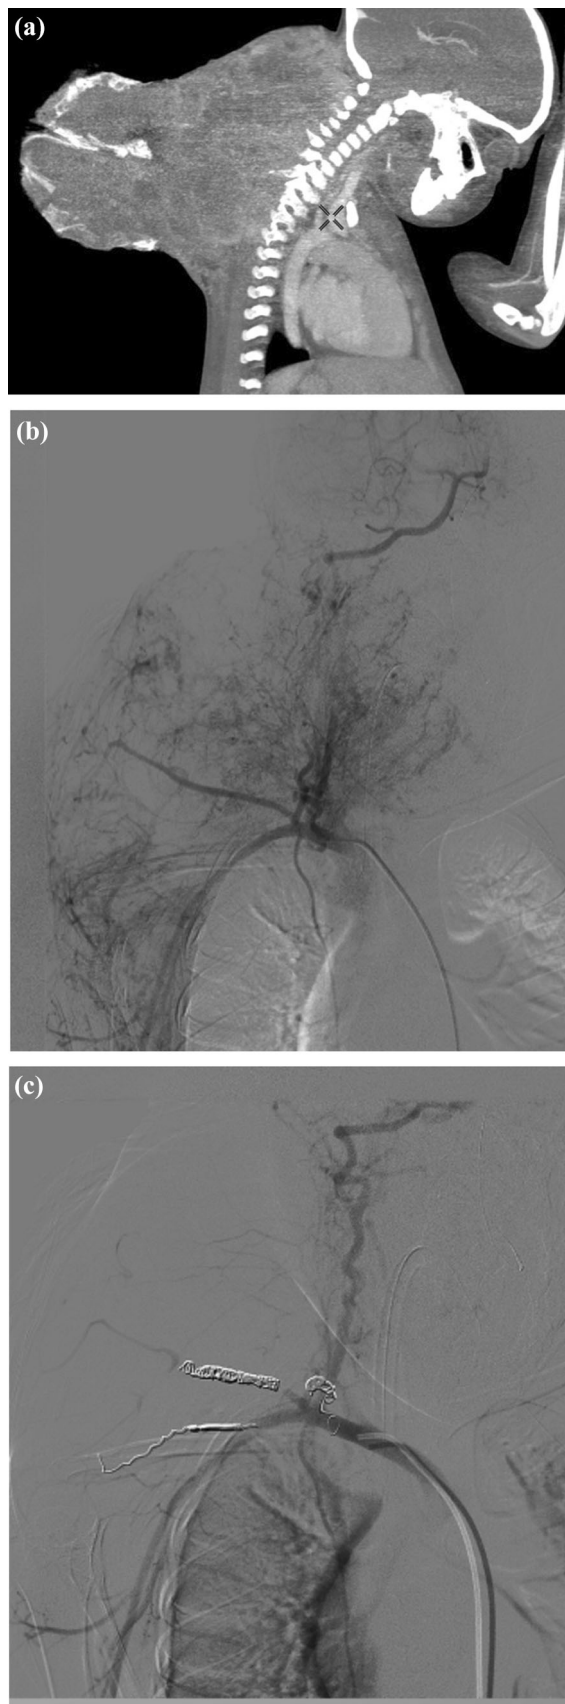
a Contrast enhanced CT in a 4-year-old boy with a cervical rhabdomyosarcoma causing pain and bleeding. b and c Digital subtraction angiography before and after bland embolization with beads (500–700 microns) and coils (ranging 3–5 mm in diameter). Observe tumor devascularization showed as reduced contrast enhancement; VAS was not evaluable due to patients condition but opioid consumption was reduced
